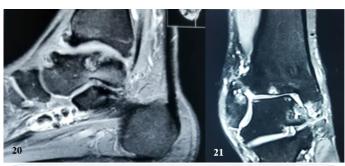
Patient 3: 46 years old male patient with PTOA Kellgren Lawrence grade 3, secondary to ankle sprain grade III. T1 and T2 ankle MRI.
